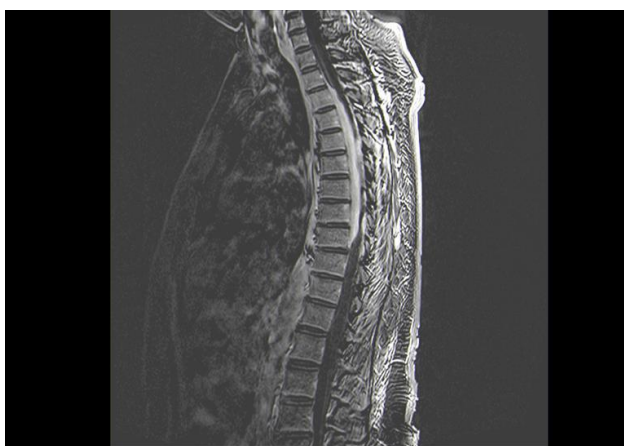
Preoperative intraspinal mass: Sagittal T1-weighted image with gadolinium reveal ventral semicircular intraspinal mass between T3 and T8 compressing the spinal cord.
